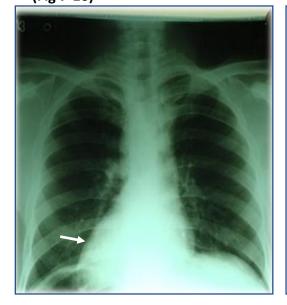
X-ray Chest dextrocardia
